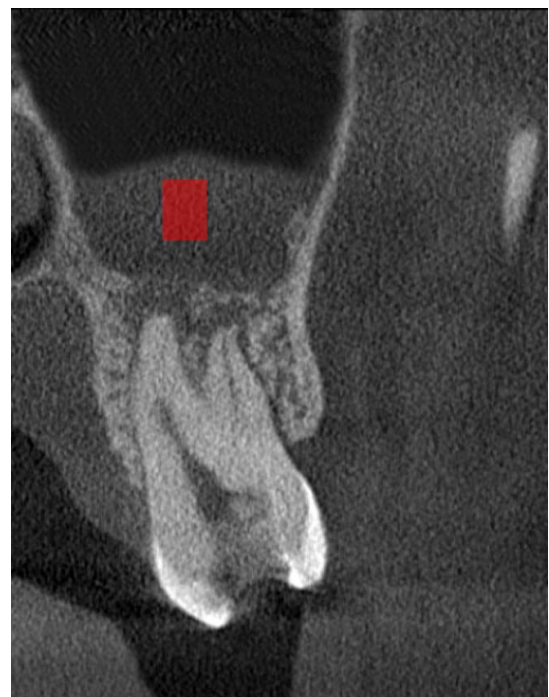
Sagittal cone-beam computed tomographic image shows a region of interest for analysis of the maxillary sinus using the MaZda software.
